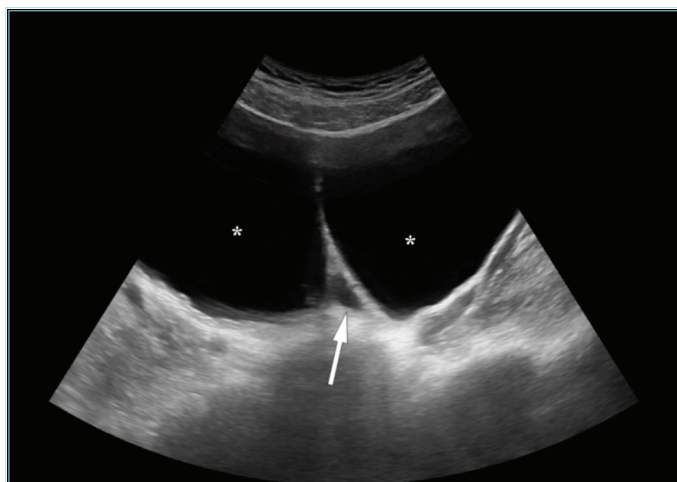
Ultrasonography image demonstrating a large volume bladder with a double lumen appearance (stars) and a dilated left ureter (arrow)
